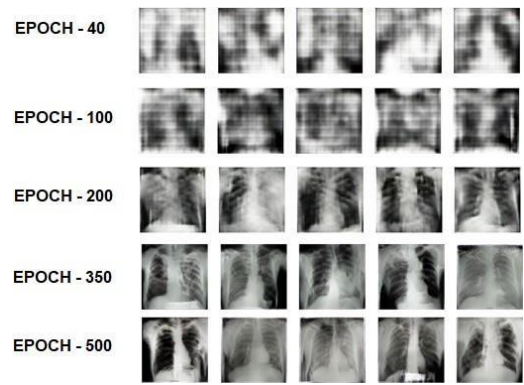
Synthetic X-ray images of Tuberculosis generated using GAN
